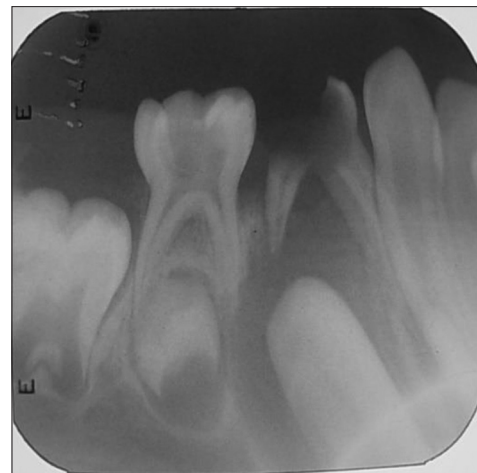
Periapical view suggestive of radiolucency at apex of the lower first molar
